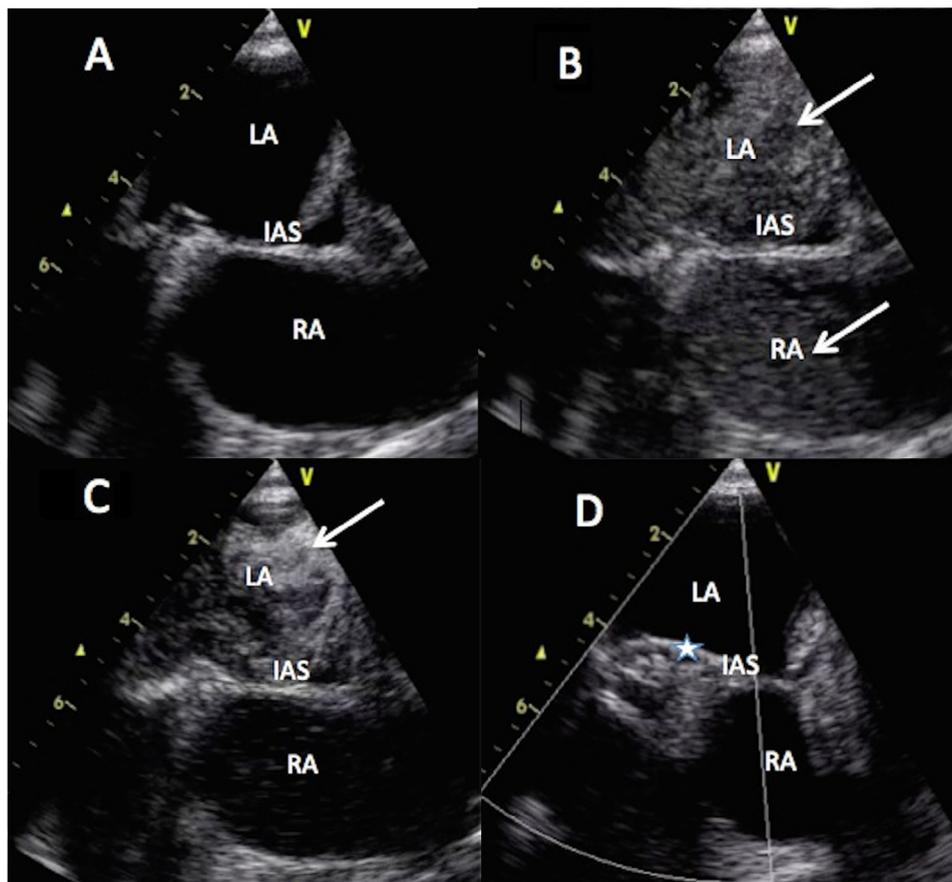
Figure A bubble study was performed with transesophageal echocardiography. (A) This image was obtained before the bubble study. (B) In the early phase of the bubble study, bubbles (arrow) moved from the right atrium (RA) to the left atrium (LA) through the interatrial septum (IAS). (C) In the late phase of the bubble study, bubbles (arrows) were located in the right atrium. (D) This image was captured after percutaneous closure of the interatrial septum (star).
